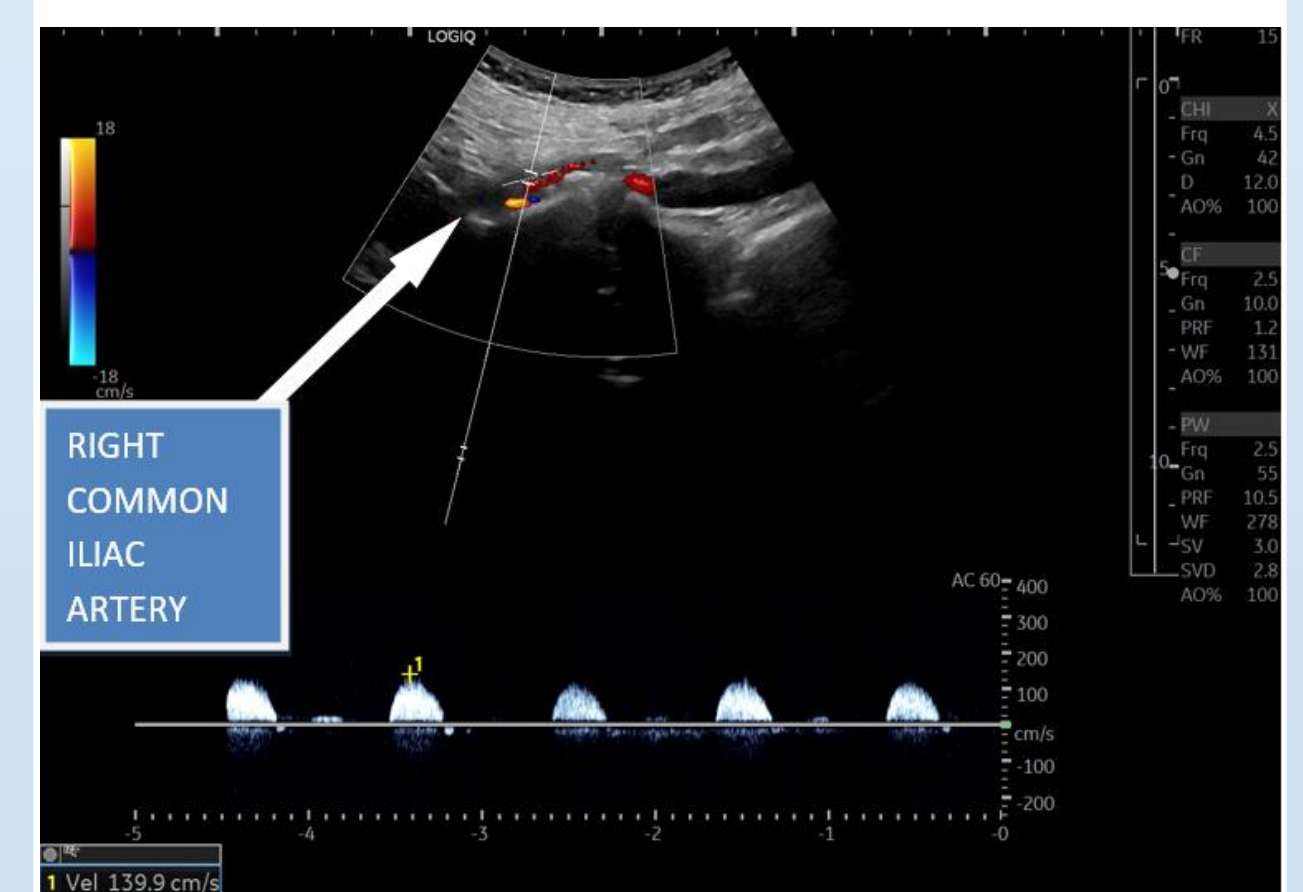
Spectral Doppler of the right common iliac artery indicating a peak systolic velocity of 140 cm/s.
